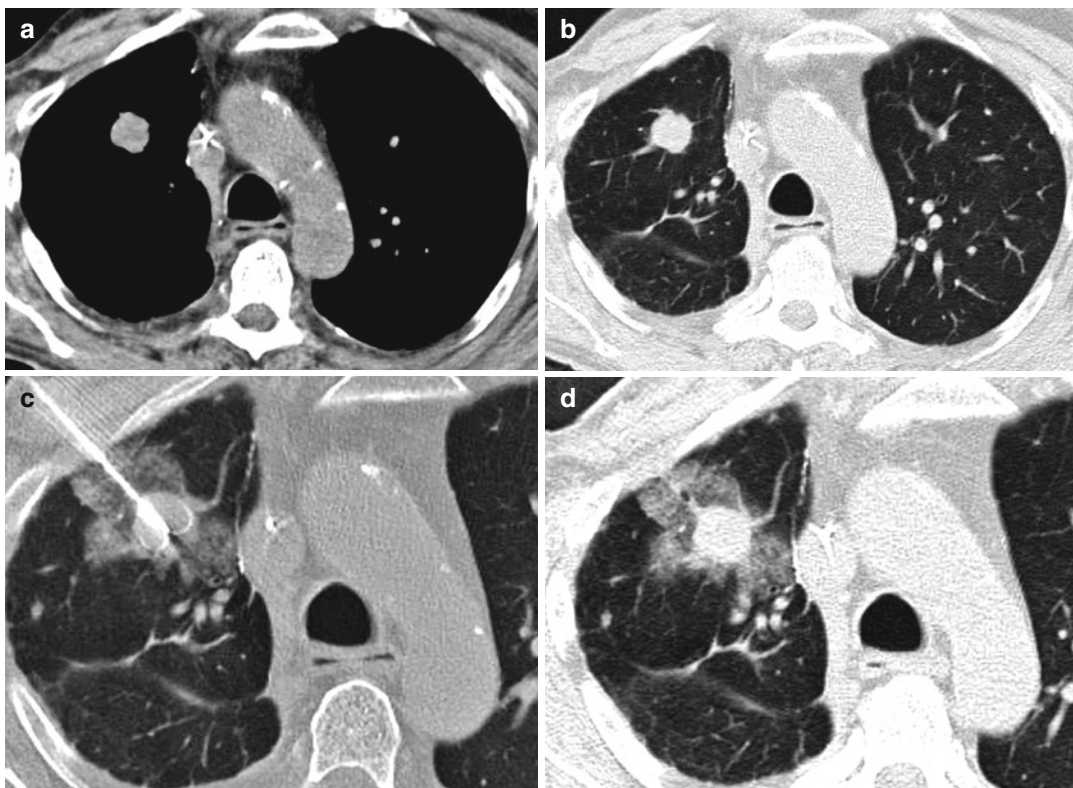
(a–d) CT-guided RF ablation of a colorectal pulmonary metastasis of the right upper lobe (a, b). During insertion of the needle electrode, self-limiting, parenchymal hemorrhage occurred (c). The CT scan
